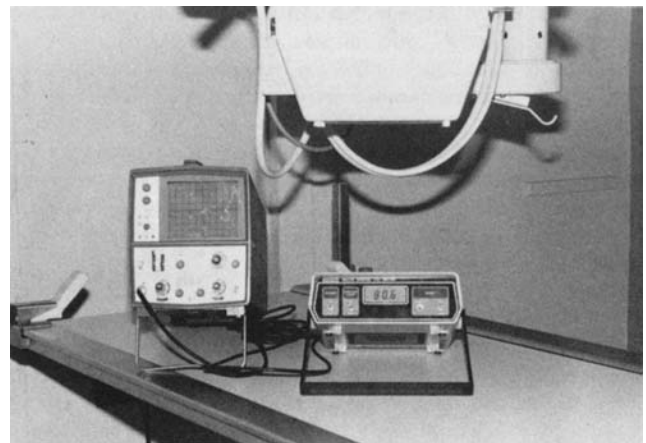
Equipment used to measure and display to peak kilovoltage of the generator. The device shown below the X-ray tube is a noninvasive peak kilovoltage meter. The storage oscilloscope is used to display the peak kilovoltage waveform.
